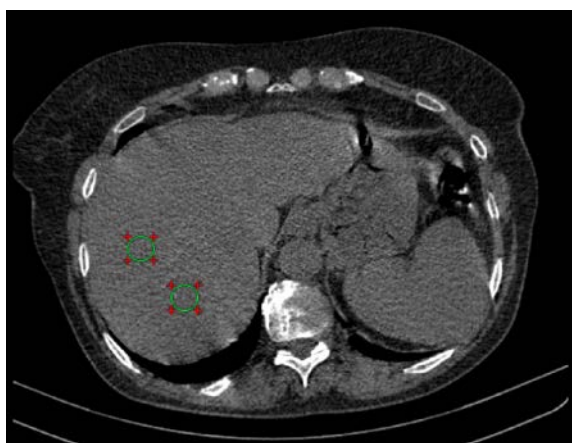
Representation of an axial non-contrast CT slice with the ROI positioned within hepatic segments VII and VIII.
